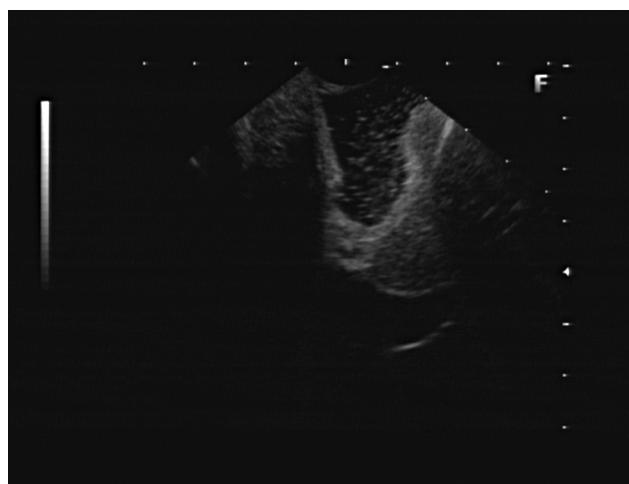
Endosonographic view of the submucosal lesion involving the 3rd and 4th sonographic layers of the duodenum. The echogenicity of the lesion was similar to that of the pancreas.
